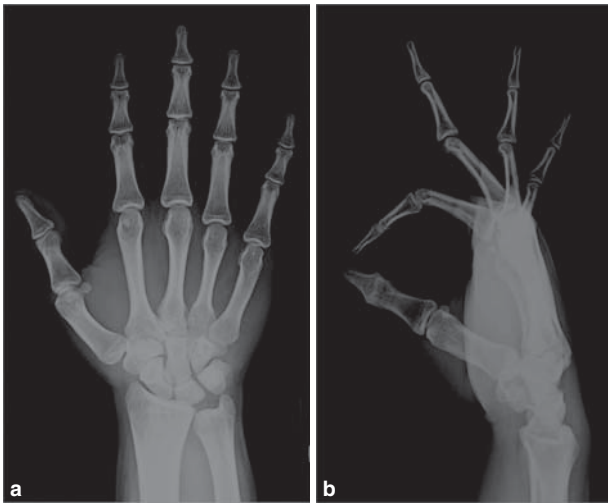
(a) Anteroposterior and (b) lateral radiographs of the hand showing a metacarpal boss at the base of the third ray.
